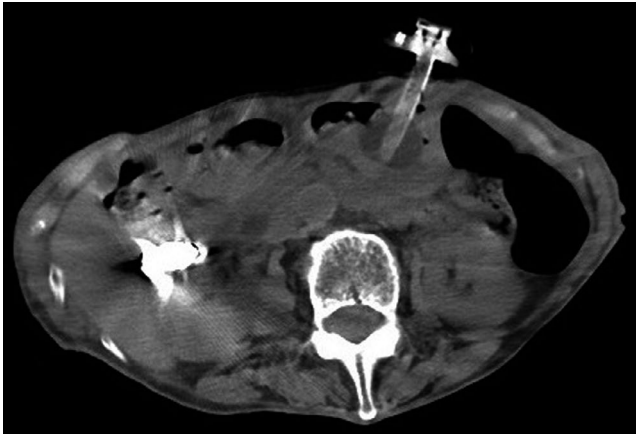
Computed tomography revealing the dental crown in the descending part of the duodenum
